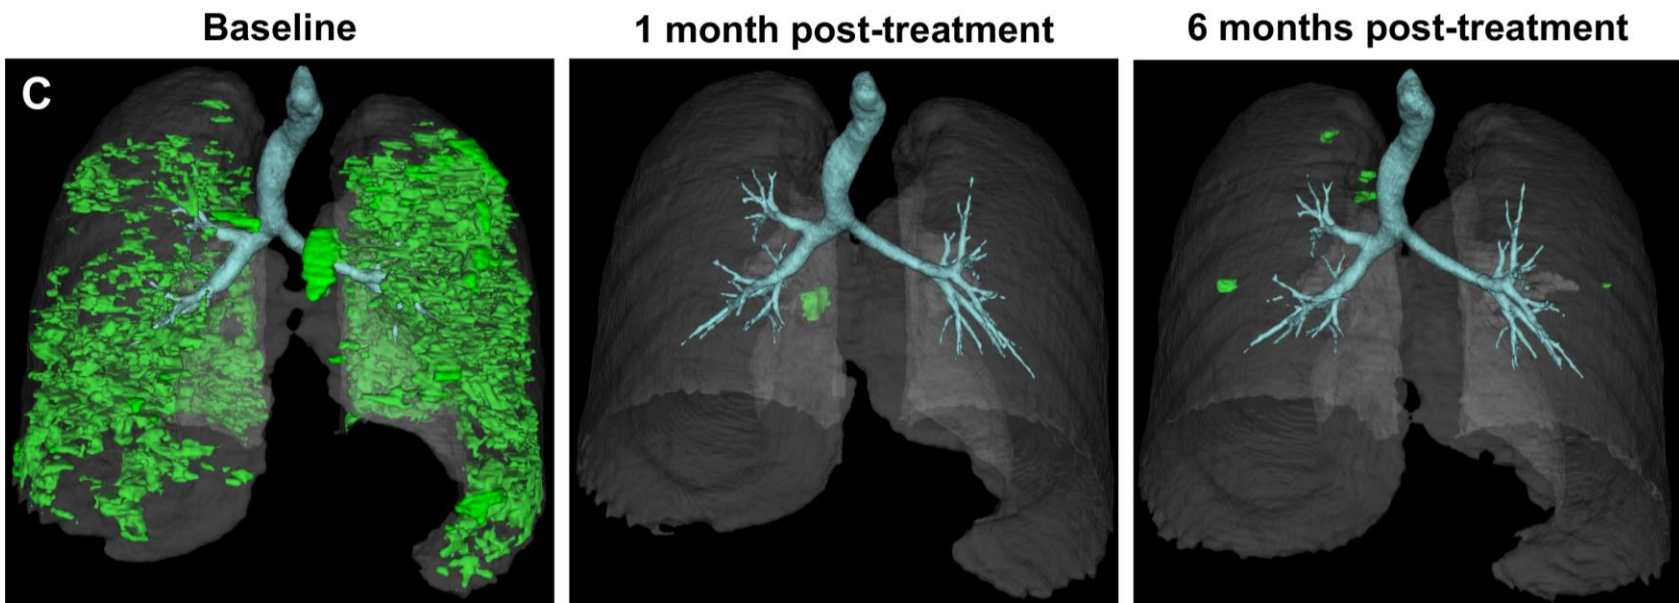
Treatment response assessed by radiography in patient 5. Shown are serial axial (A) and coronal (B) chest CT images and coronal 3D reconstructed CT images (C) at baseline and at 1 and 6 months after treatment initiation.
